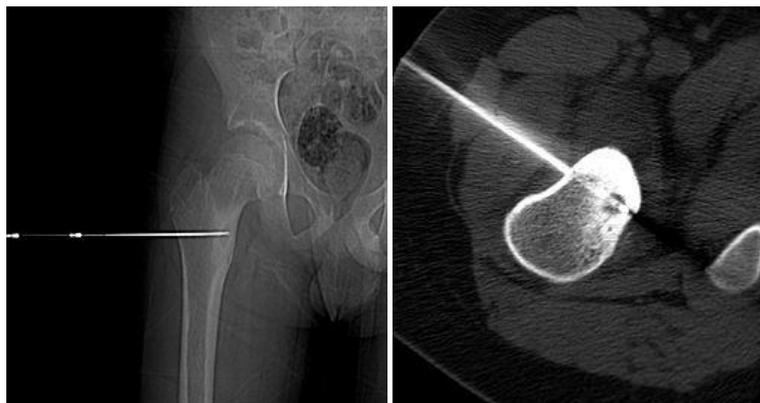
CT guided targeting of the nidus
